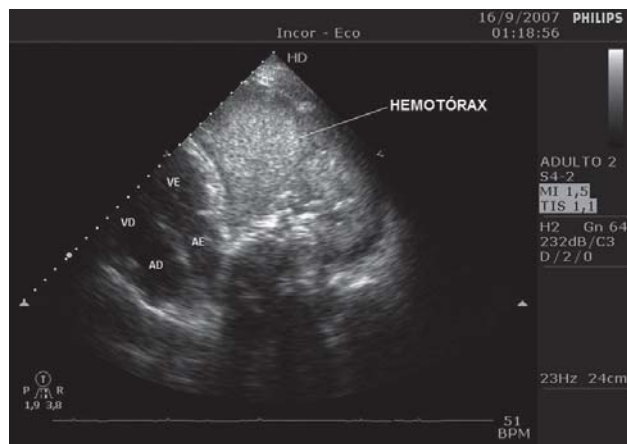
Transthoracic echocardiography showing image of increased density compatible with blood, located in the left pleural space
